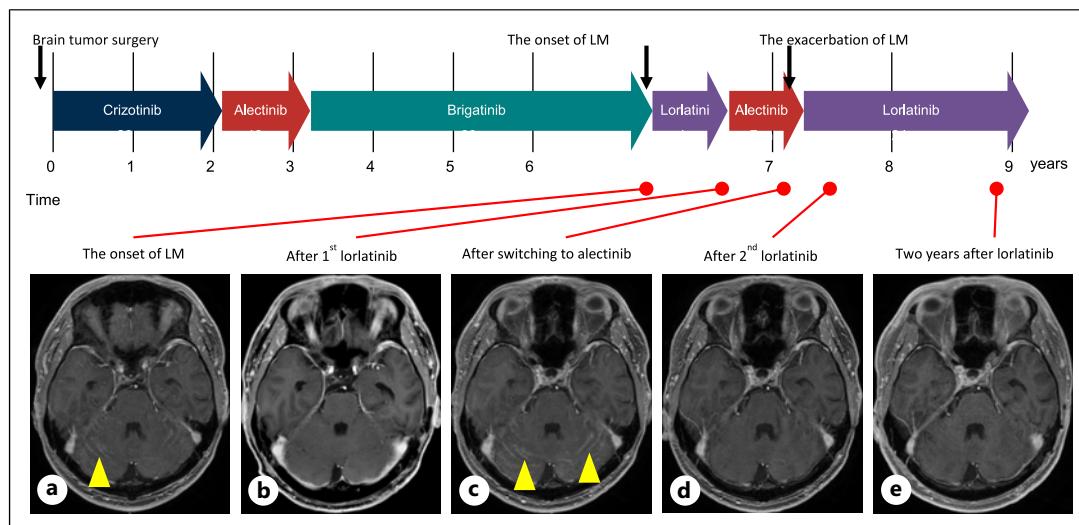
Timeline of the patient's treatment history and representative brain MRI. Brain MRI at the onset of LM (a), after 1st lorlatinib (b), after switching to alectinib (c), after 2nd lorlatinib (d), and at present (e). Yellow arrow: leptomeningeal metastases. LM, leptomeningeal metastases; MRI, magnetic resonance imaging.
